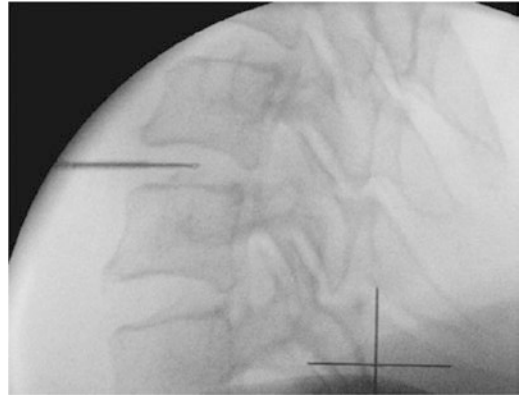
a Lateral X-ray of the cervical spine showing the needle trocar in the posterior third of the disc space to be treated. b X-ray of the cervical spine from ventral (a.p. projection) showing the needle trocar in the middle of the disc space to be treated. For the correct
